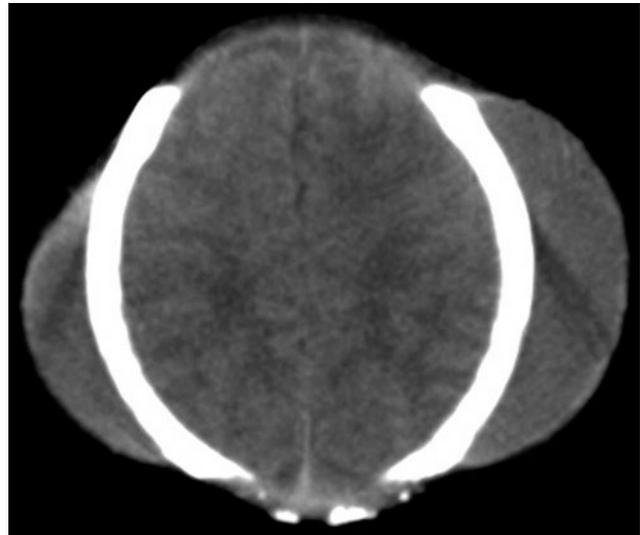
Cephalohematoma. Computed tomographic scan of the head showing the typical appearance of bilateral cephalohematomas.
